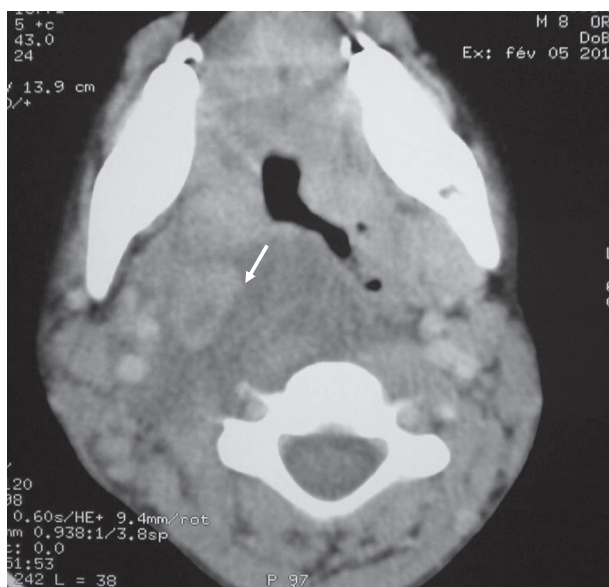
CT scan of the oropharynx in axial view demonstrating a heterogeneous oropharyngeal tumor (arrow).
